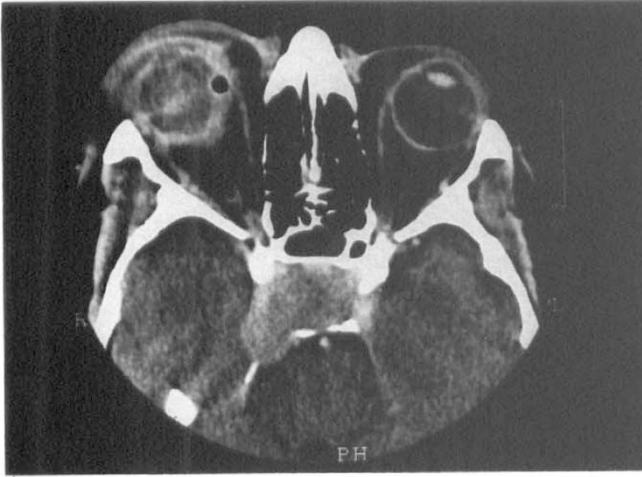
Axial CT scan showing a pituitary tumour invading the right cavernous sinus. Proptosis of the right eye is also seen together with thickening of the sclera. Note: one end of the plomb is seen medially next to the globe.
